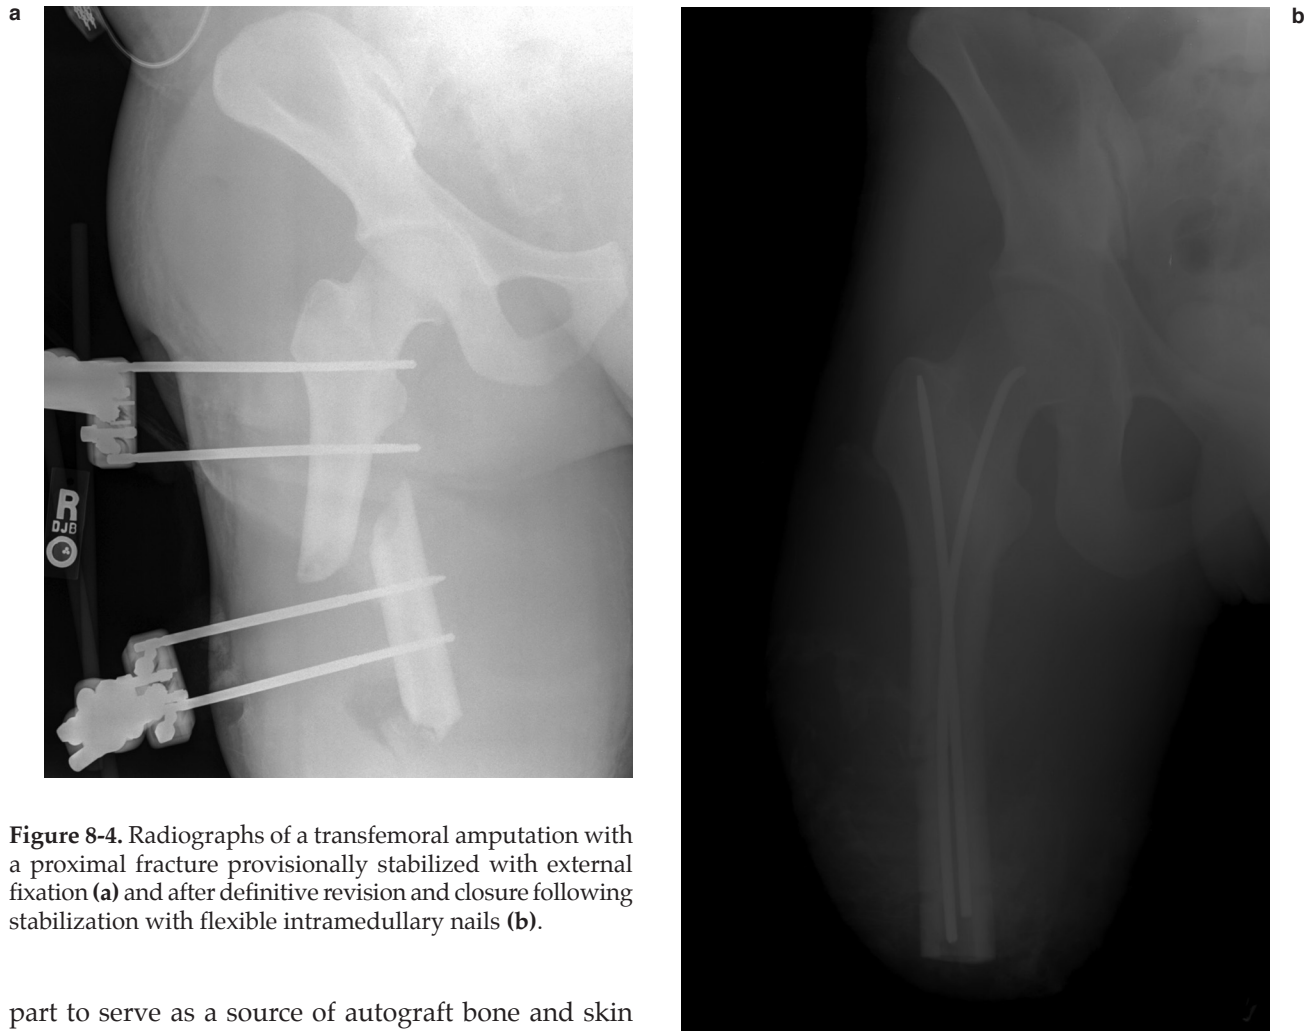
Radiographs of a transfemoral amputation with a proximal fracture provisionally stabilized with external fixation (a) and after definitive revision and closure following stabilization with flexible intramedullary nails (b).
